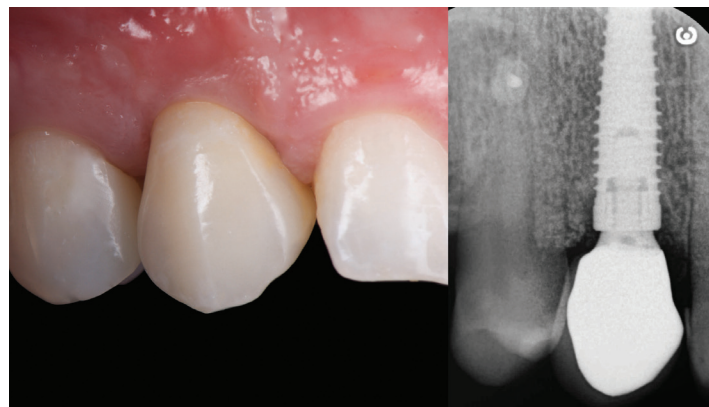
Clinical (left) and radiographic (right) view at definitive prosthesis fitting.
